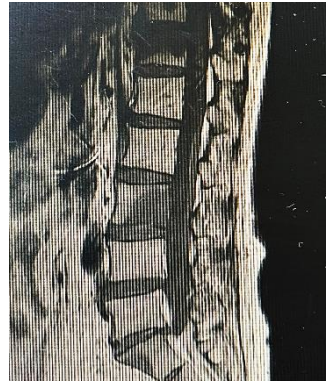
Pre-Kyphoplasty Sagittal MRI Of The Lumbar Spine Showing Vertebral Compression Fractures At L2-L4 With Metastatic Involvement and Spinal Canal Narrowing
